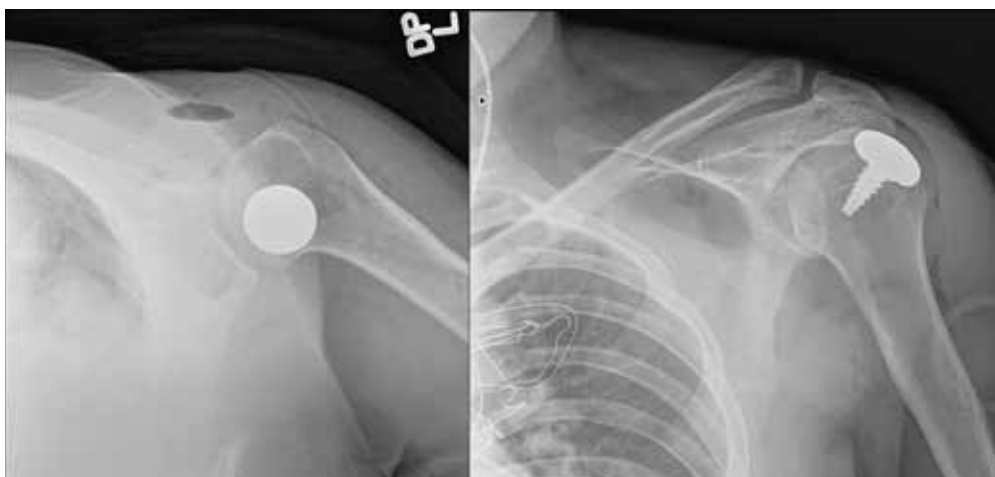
Two radiographic views of prosthetic implant filling the void created by a large posterosuperior Hill-Sachs defect.
